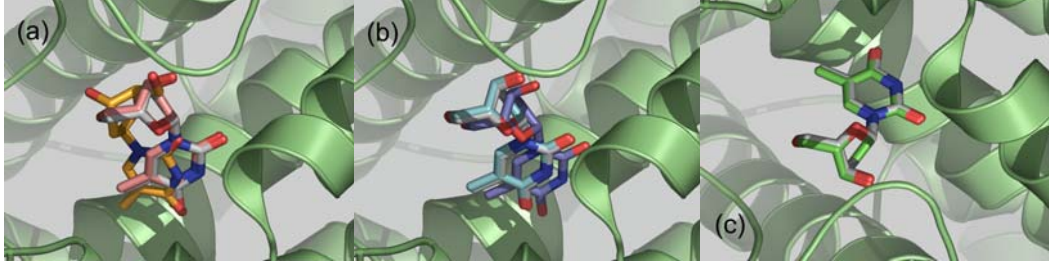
Docking of dT into the 1KIM binding pocket. (a) The docked poses by GAsDock with single scoring function. RMSD values compared with X-ray pose are 0.23 Å and 2.64 Å to energy score and contact score, respectively. (b) The docked pose of MOSFOM by ε -MOEA method. RMSD values are 0.21 Å and 0.55 Å to MOEA_Nrg and MOEA_Cnt. (3) The docked pose of MOSFOM by EFMOGA method with a RMSD value of 0.22 Å. The following color coding was used: X-ray pose, white carbon atoms; energy score pose, incarnadine carbon atoms; contact score pose, yellow carbon atoms; MOEA_Nrg pose, blue carbon atoms; MOEA_Cnt pose, cyan carbon atoms; EFMOGA pose, green carbon atoms.
